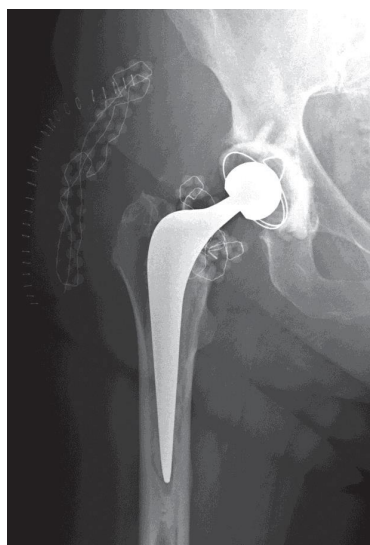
THR with gentamicin-PMMA beads intra-articularly around the neck of the prosthesis and in the subcutaneous tissues. Antero-posterior radiograph on the first day after the debridement operation. Only a limited number of beads could be placed in this joint after the debridement. In the subcutaneous tissue, beads were placed in an abscess cavity.
